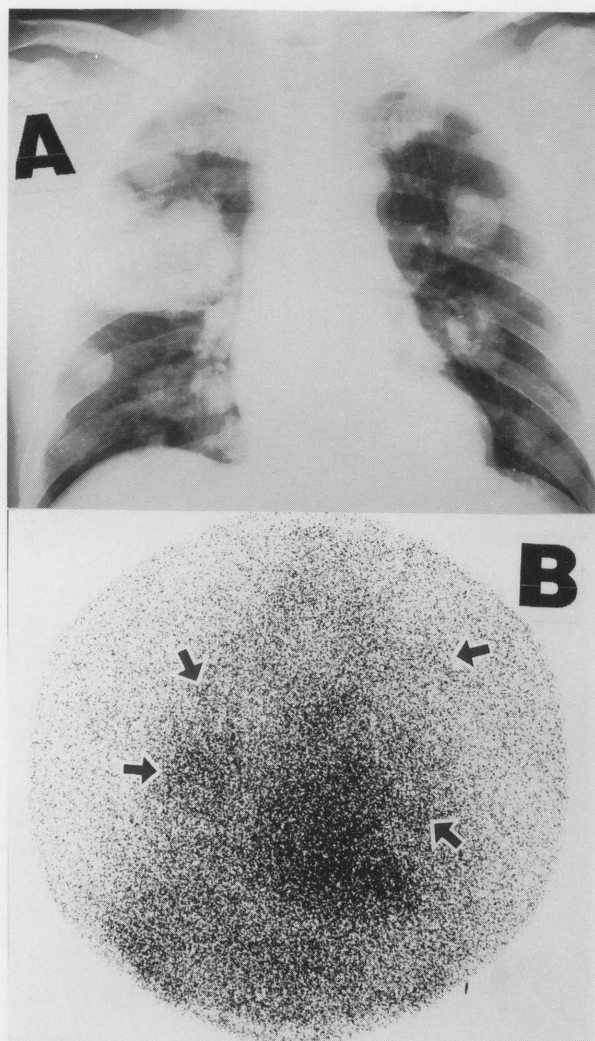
(A) Chest X-ray of patient whose primary tumor was in the rectum shows multiple metastatic foci in both lungs. (B) Radionuclide imaging shows accumulation of radiolabeled Mab in the corresponding metastatic foci in lungs (arrows).
